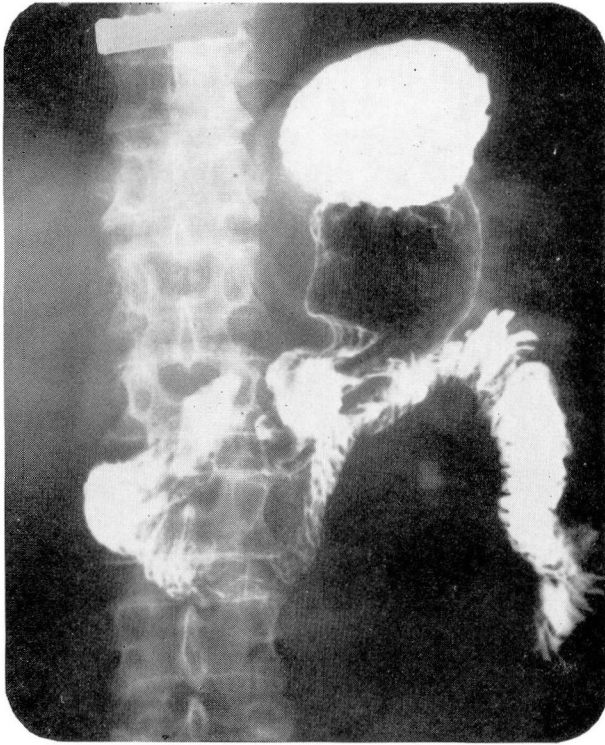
Roentgenogram showing effacement of the duodenal mucosa and spikes on the medial wall.
